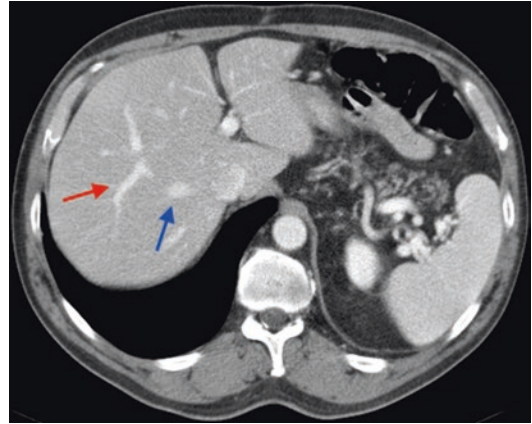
CT scan at the level of the sub-segmental branches of S8. Branches from S8 (red arrow) extend behind the right hepatic vein (blue arrow)
